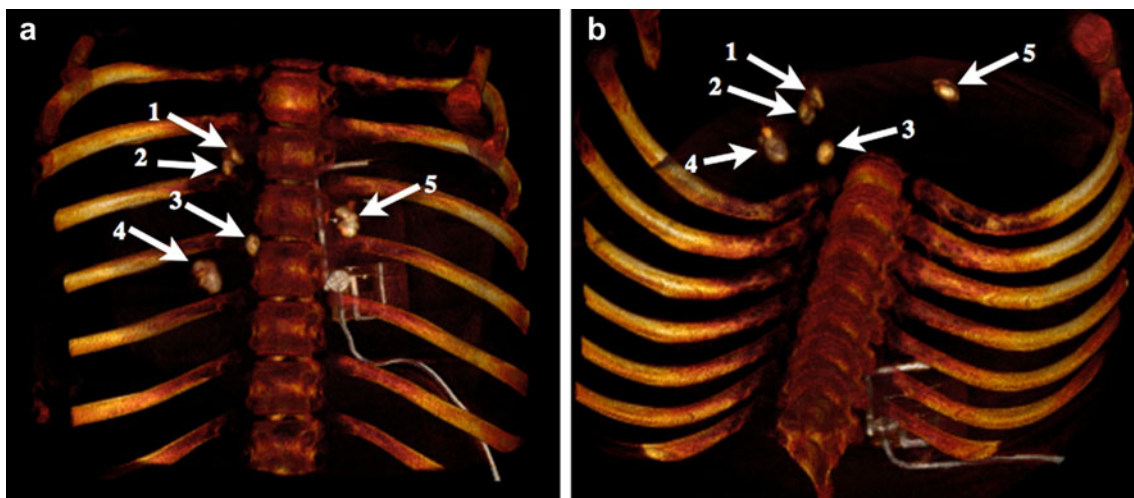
Volume rendering (thresholded) of a cone beam computed tomography volume showing five tumors in the liver. a Approximately anteroposterior view. b Volume slightly tilted for better view of the tumors.
